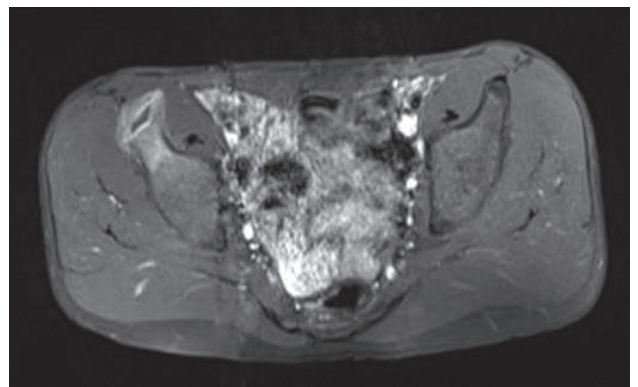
There were no signs of calcification or malignancy detected at MRI examination. Post-contrast axial image shows a cystic lesion with peripheral enhancement.
